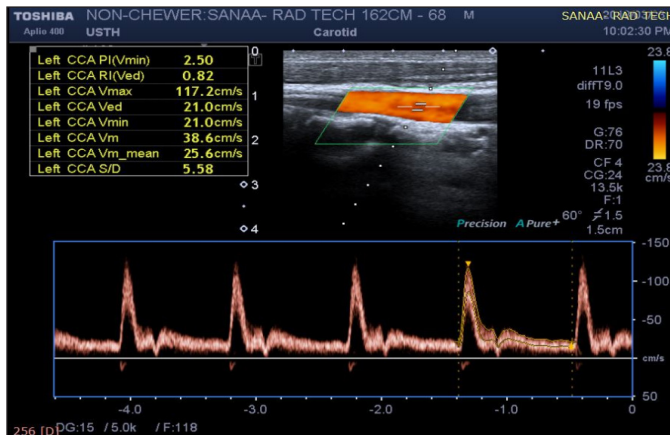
Doppler interrogation of Lt CCA hemodynamics for non-Khat chewer participant
